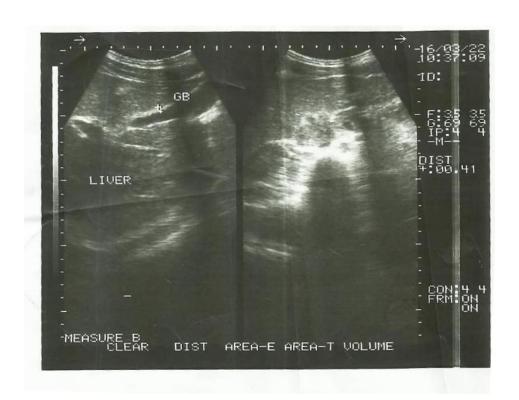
Ultrasound of 28y old male,positive HCV showed normal liver finding with thickened GB wall(4mm).
